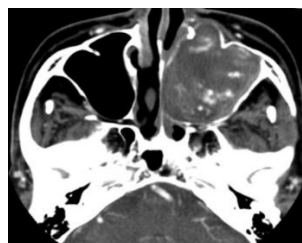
Axial CT showing a soft tissue lesion in the left maxillary sinus extending into the left nasal cavity
